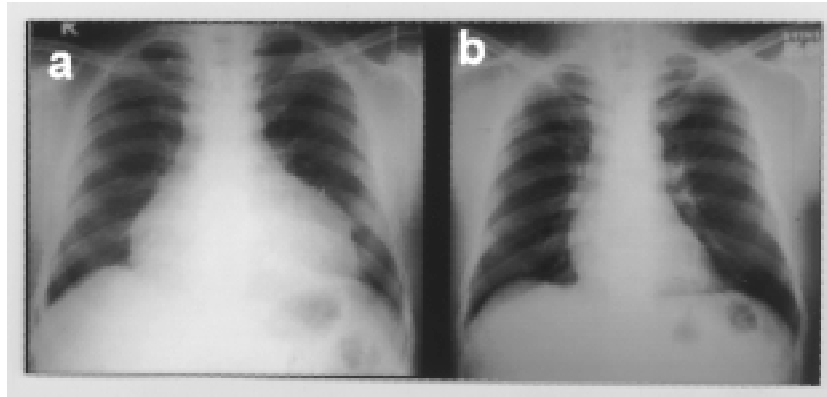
Chest radiograph (postero-anterior view) of a patient with tuberculosis pericardial effusion showing a globular heart shadow (a) before treatment. Chest radiograph taken 9 months after antituberculous treatment (b) reveals considerable resolution of the pericardial effusion.
